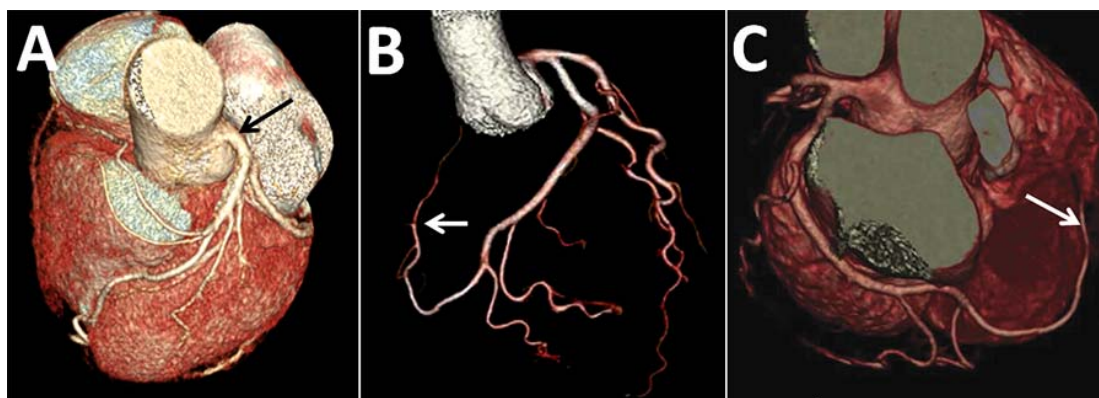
A 35-year-old woman presented to the emergency department with chest pain. Dual-source computed tomography coronary angiography- three-dimensional volume-rendered (A, B and C) images depicting the single coronary artery ostium off of the left sinus of Valsalva (A, black arrow) and left circumflex artery extending around the right atrioventricular groove supplied RCA territory (B and C, white arrows). Volume-rendered 3-dimensional reconstruction of the coronary arteries showing the single coronary artery ostium off of the left sinus of Valsalva and the extensive left circumflex artery.
